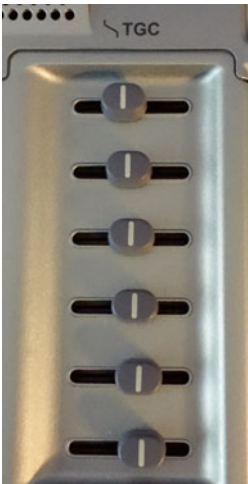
Showing ultrasound image obtained by incorrect TGC setting in the near field
